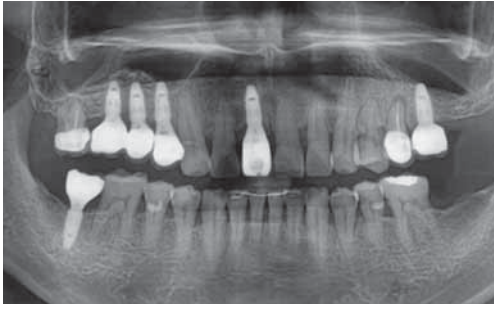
4 years postloading radiograph. All implants are successfully maintained without bone loss.
